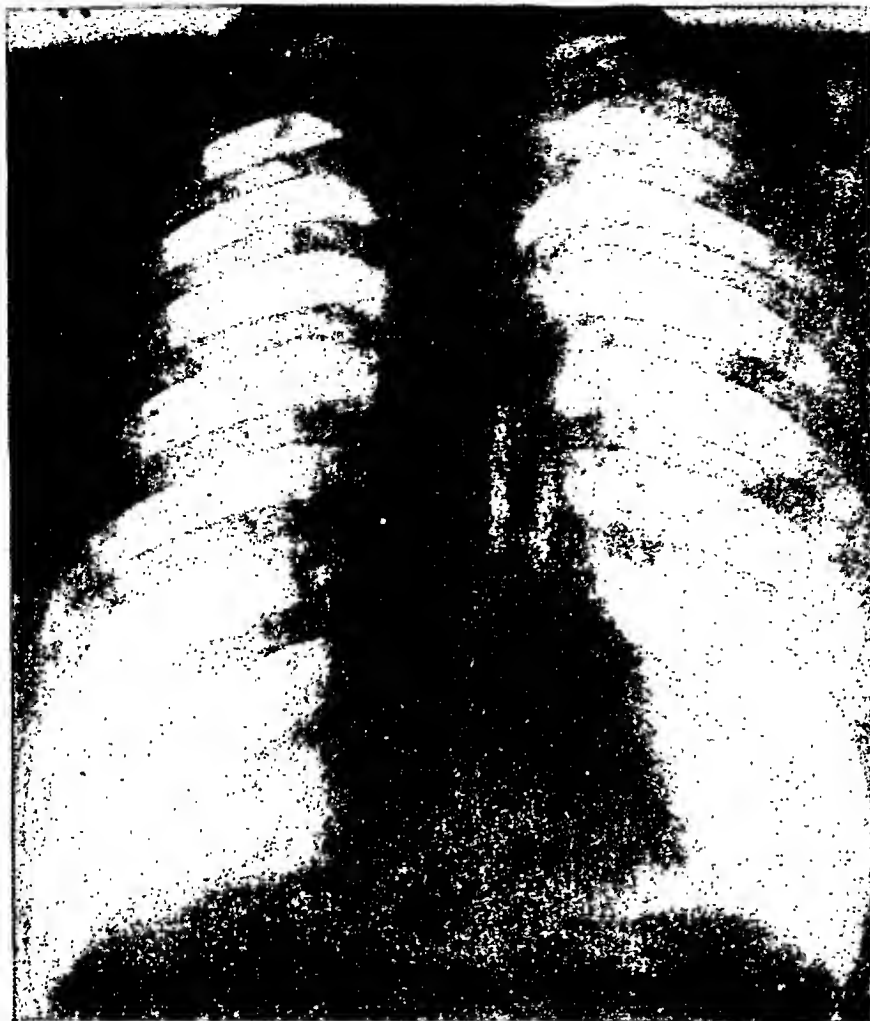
Radiograph in Case 45, showing normal appearance of heart and aorta. Necropsy showed severe syphilitic aortitis with stenosis of both coronary ostia.
